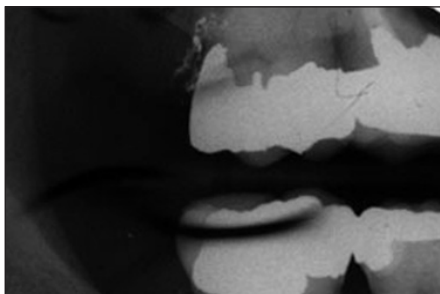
Radiographic image of the corrected restorations with long diamond and finishing burs.
